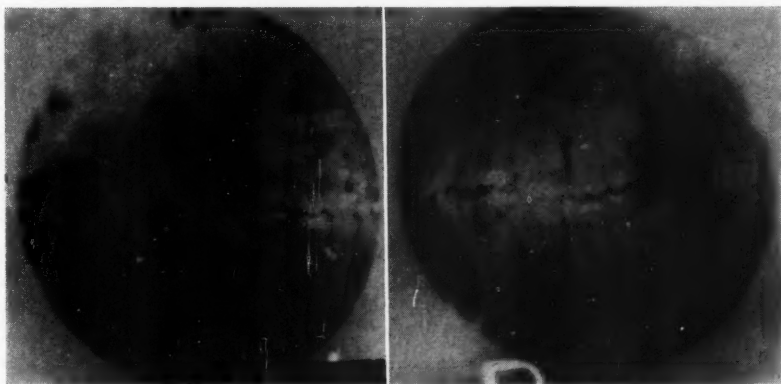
Case 1. Molars at finish of treatment. The arch apparently is not large enough to contain sixteen teeth. When this roentgenogram was taken, the incisors were "straight."
